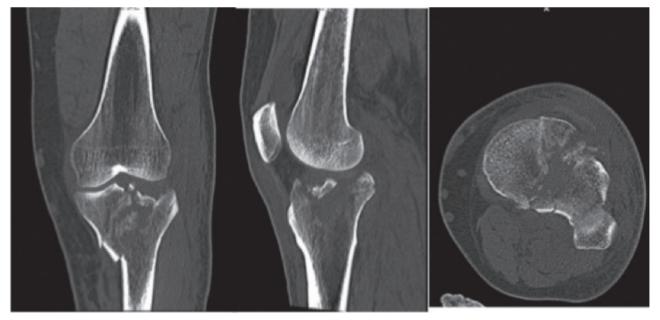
CT series have demonstrated a comminuted intraarticular fracture affecting ACL and PCL attachment on tibia
